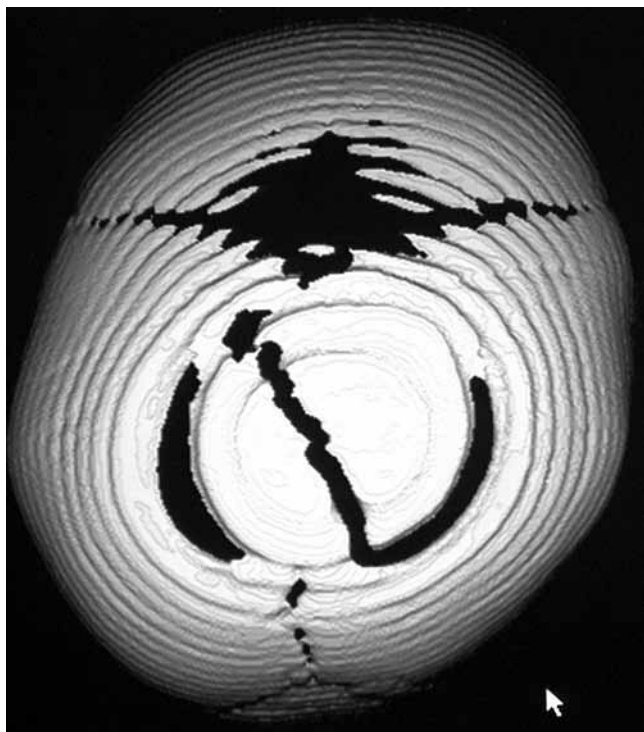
Inferior view of 3D CT of plagiocephalic skull.
